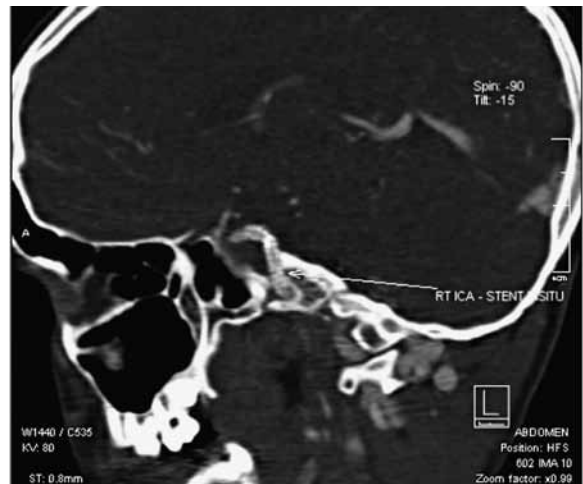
Follow-up CT angiography at 1 week confir- → med ICA patency at the level of the stent-graft, with non opacification of the aneurysmal sac.
